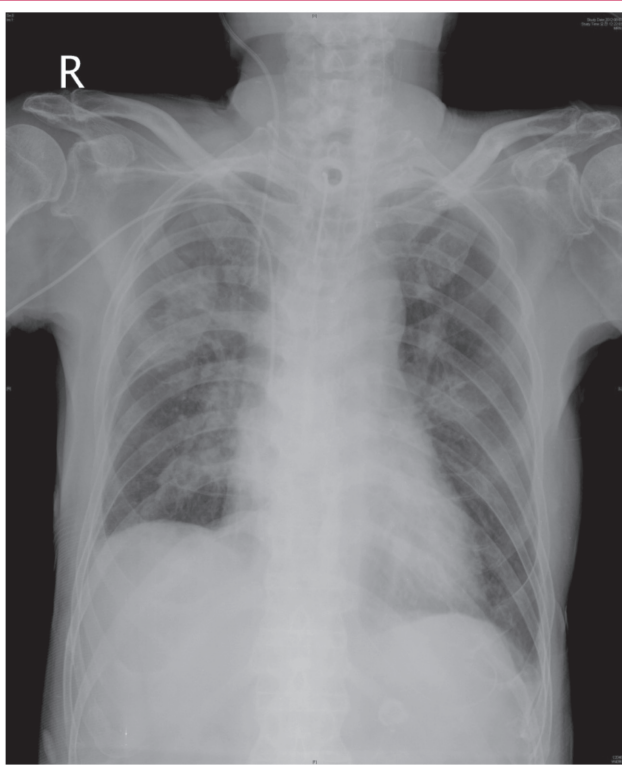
Chest X-ray showing cardiomegaly with mild pulmonary congestion and pleural effusion from both lungs. However, consolidation on the right upper lung field shows no interval change compared with the previous X-ray.
